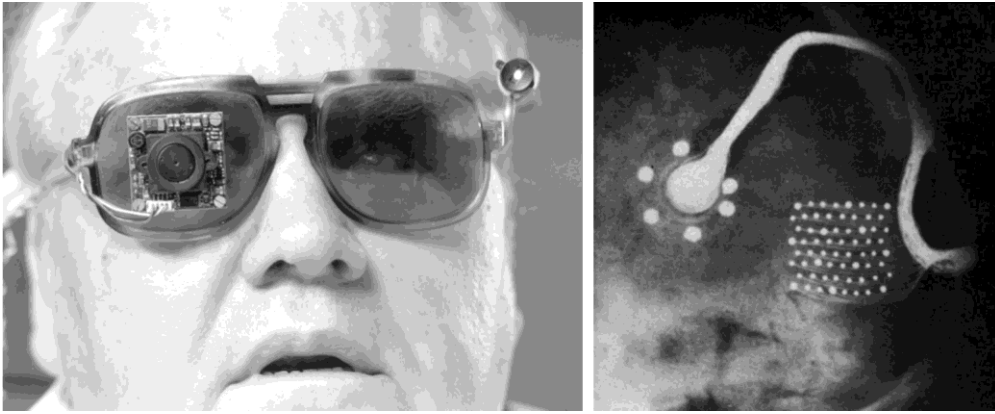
The Dobbelle bionic eye. (Left): a blind subject wearing glasses with attached video camera. (Right): X-ray image showing the percutaneous connector and array of cortical electrodes. Reused with permission from Dobbelle (1976, 2000).<sup>52,243</sup>
